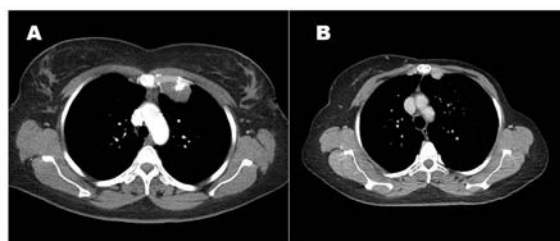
CT scan of the chest showing osteosarcoma involving the left edge of the manubrium (A) and breast metastasis at the lateral border of the manubrium (B)
